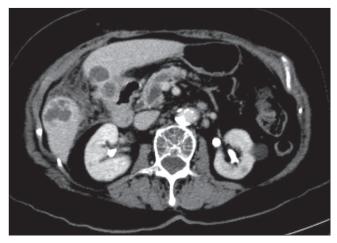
Abdominal computed tomography at the first admission revealed multiple multi-loculated cystic lesions over S3, S4 and S5
